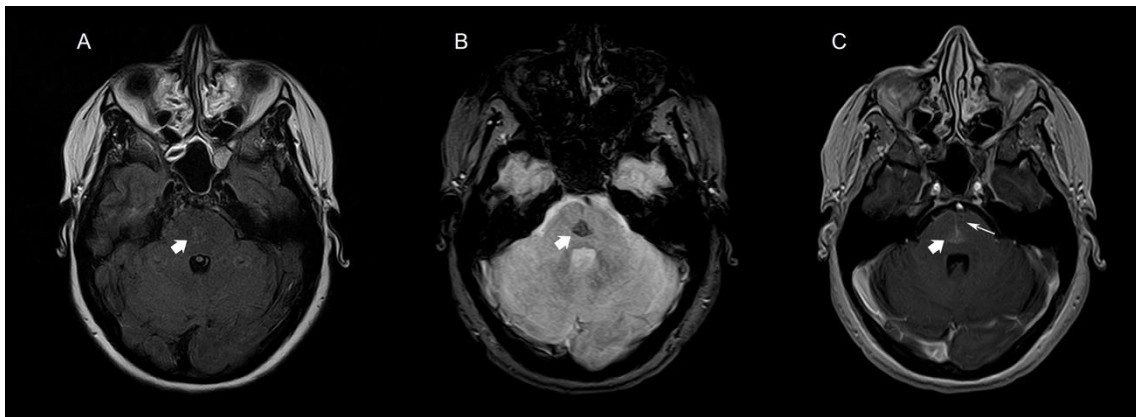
Brain MRI including axial FLAIR (A), SWI (B) and contrast-enhanced T1WI (C) images obtained in a male teenager depicts a very subtle area of FLAIR hyperintensity within the pons, with marked susceptibility effect and faint enhancement after gadolinium injection (*thick white arrows*), compatible with a capillary telangiectasia. Also note an adjacent venous collector draining anteriorly, corresponding to an associated developmental venous anomaly (*thin white arrow*).
